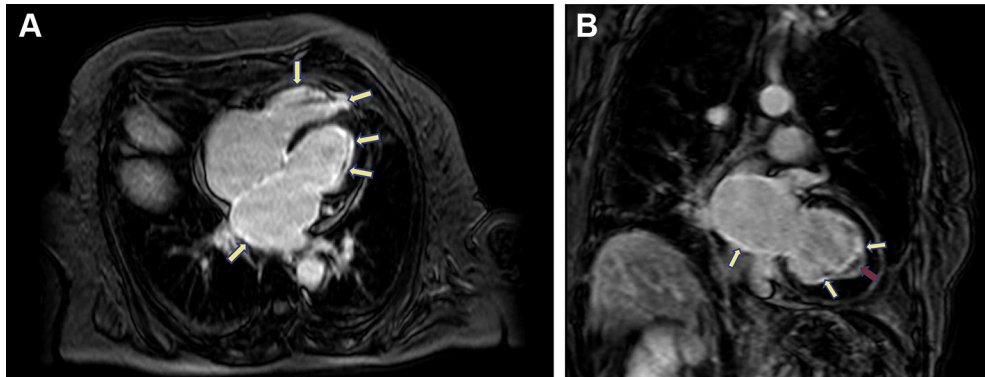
(A) Cardiac magnetic resonance imaging, four-chamber image showing biatrial dilatation and the presence of severe sub-endocardial fibrosis (yellow arrows) in the late gadolinium enhancement sequences. (B) Two-chamber image showing left atrial dilatation and the presence of subendocardial fibrosis (yellow arrows) in the late gadolinium enhancement sequences and small hypointense lesions (red arrow) consistent with a thrombus at the apex.
